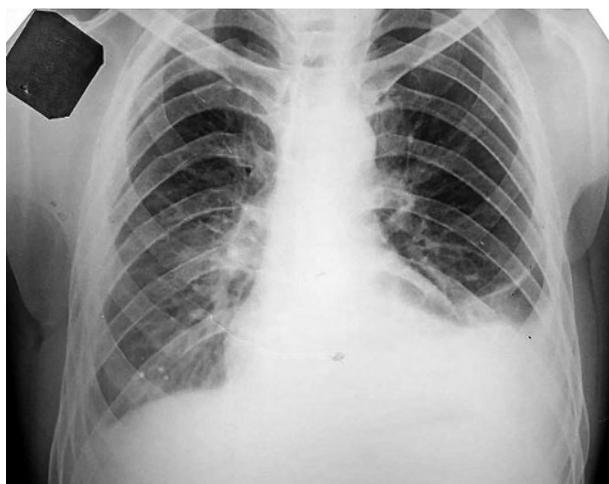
A 35-year-old man; chest X-ray shows positive changes after the intensive phase of anti-tuberculosis treatment, in form of resorption of the pleural effusion shadow
